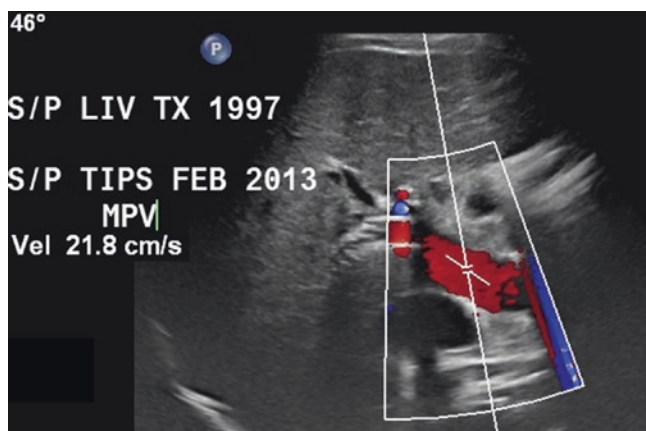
Main portal vein. Color doppler US of the liver post TIPS shows of a patent TIPS shunt with main portal vein velocities slightly decreased compared with previous examination
